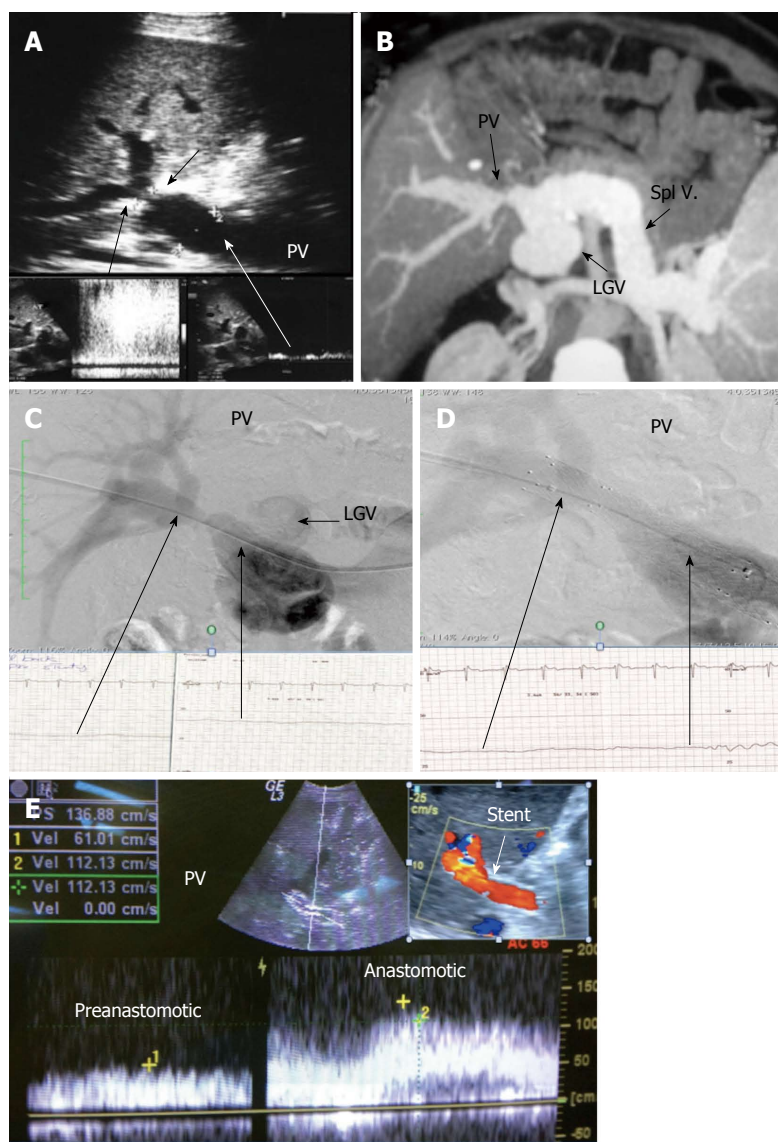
Post-operative developmental portal vein stenosis in a patient with attack of variceal bleeding, 1-year post-living donor liver transplantation. A: B-mode and pulsed Doppler image showing tight PV anastomotic stricture (arrows) and anastomotic jet (> 10 -fold) compared to the pre-anastomotic velocity; B: MSCT angiography image demonstrating tight PV anastomotic stricture with aneurysmal dilatation of the left gastric vein; C: Percutaneous trans-hepatic portography demonstrating tight PV stricture and dilated left gastric vein, stealing the portal flow. The pressure gradient was 10 mmHg; D: Control portography after balloon dilatation and stent placement demonstrating wide anastomosis, normalization of the pressure gradient, improvement of the flow steal and disappearance of the left gastric vein filling; E: Color Doppler image after PV stent placement confirming improved portal flow with increased pre-anastomotic velocity and mild elevation of the anastomotic velocity. PV: Portal vein; LGV: Left gastric vein.
